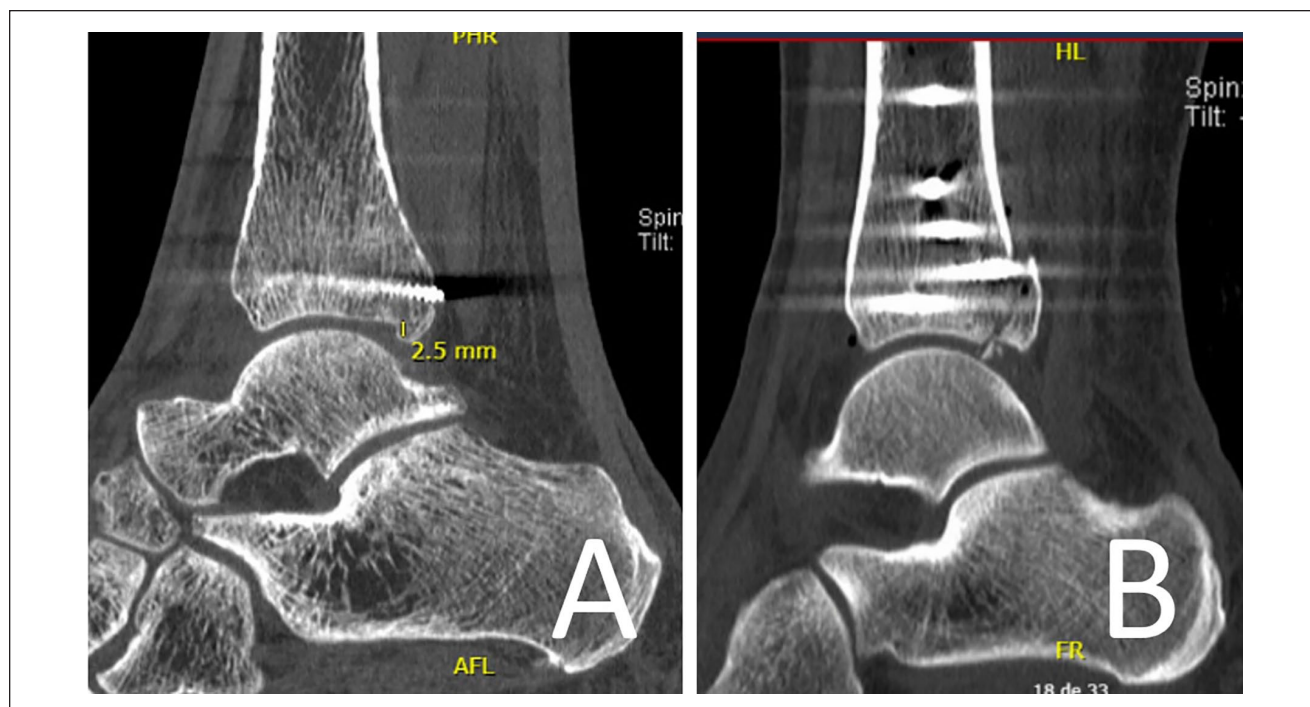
Sagittal computed tomographic scan showing how we measure step-off. (A) Malreduction secondary to articular impaction. (B) Step-off secondary to a posterolateral fragment malreduction.
